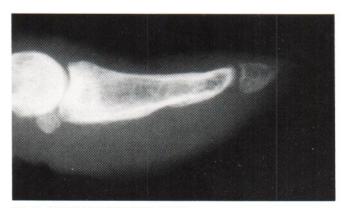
Roentgenogram of the thumb.
